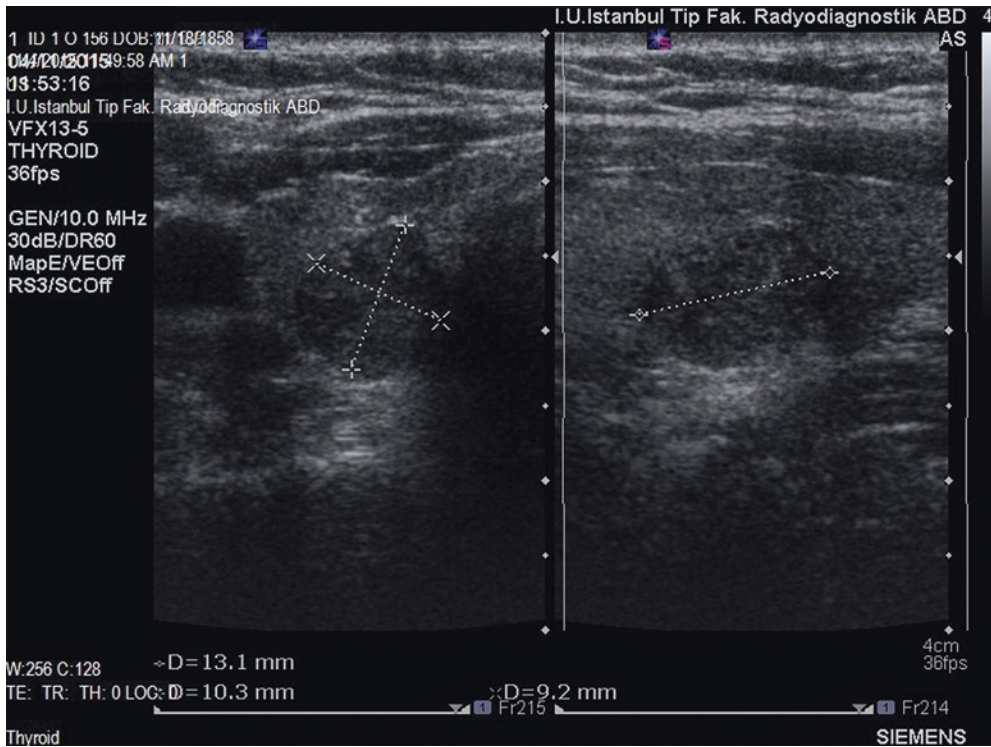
Sonographic image of the dominant thyroid nodule in the right lobe showing iso-hyperechoic nodule with regular borders
